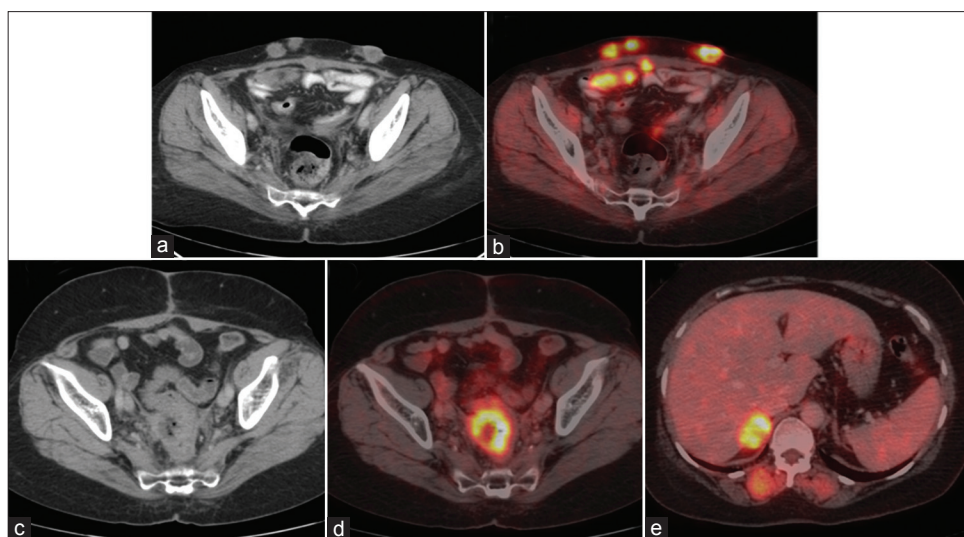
F-18 FDG PET/CT transaxial images (a) CT and (b) fused PET and CT of a patient with cervix cancer on follow-up showing abdominal wall metastasis. Transaxial CT image (c) and fused PET and CT image (d) of another patient reveal metastasis in the rectosigmoidal region; fused PET and CT image (e) of a third patient showing right adrenal metastasis
